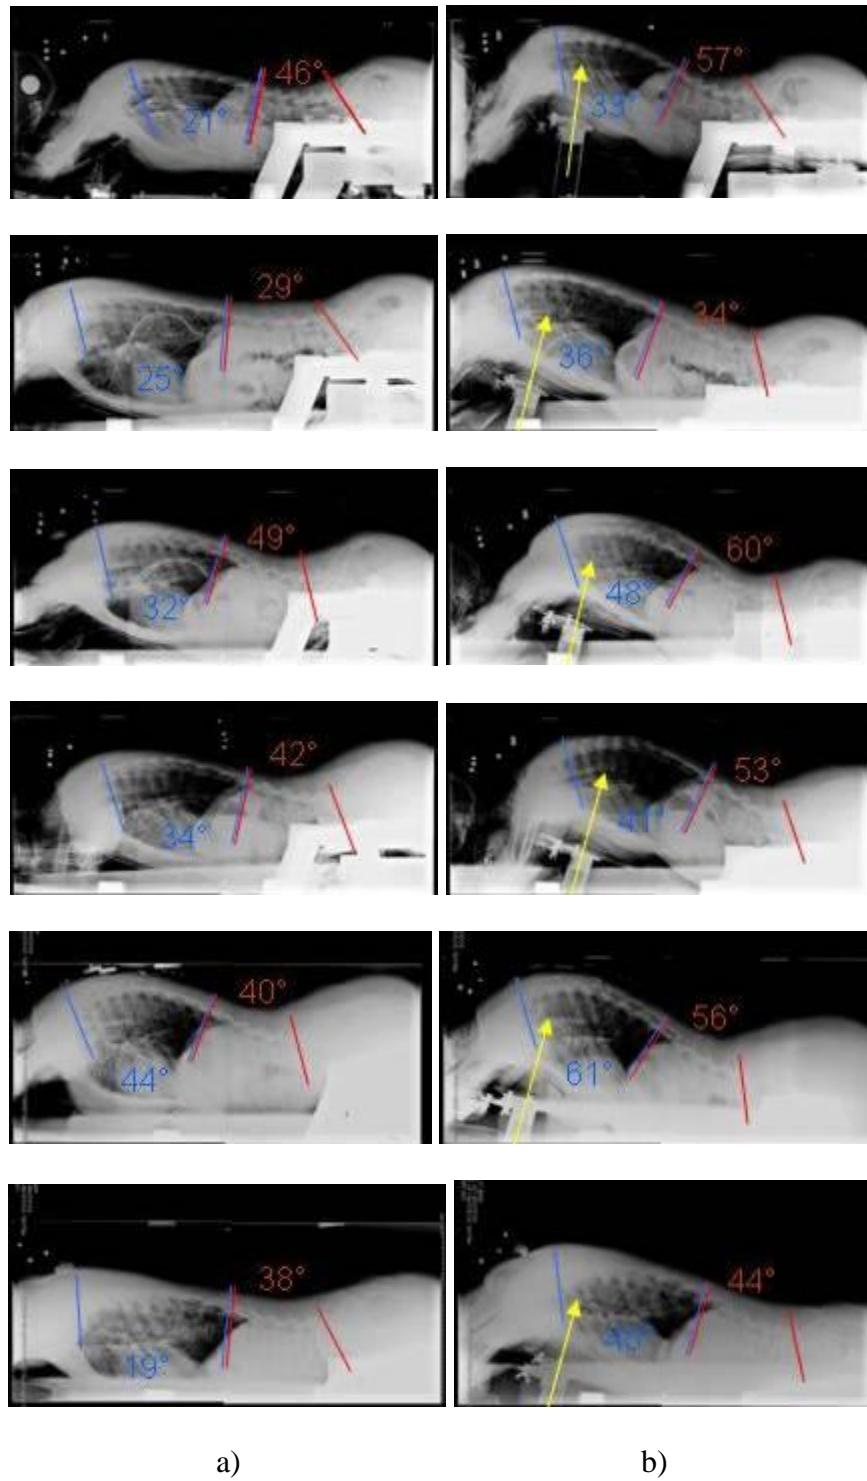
(A3F2): Radiographs of subjects 1 to 6 in the a) neutral b) raised positions
